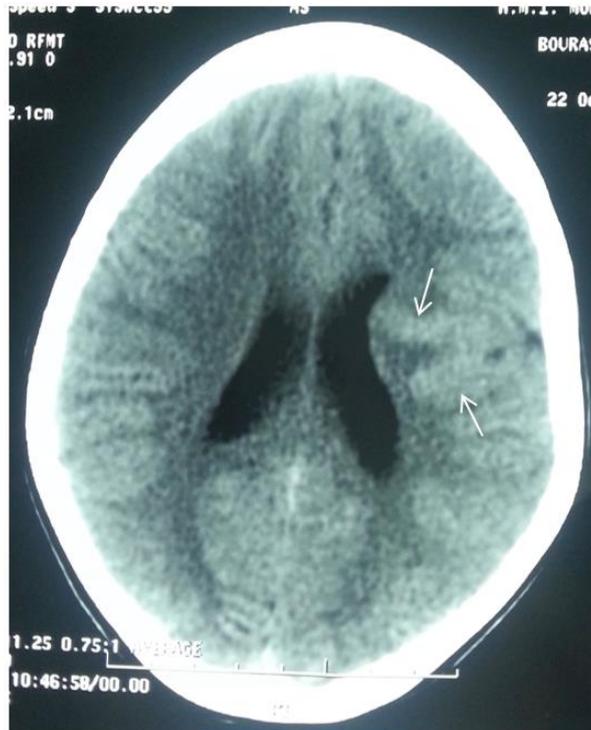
Cerebral CT: axial section showing two left parietal hyperdensities describing a 'V' (arrows) extending into the adjacent white matter up to the ventricular rim
